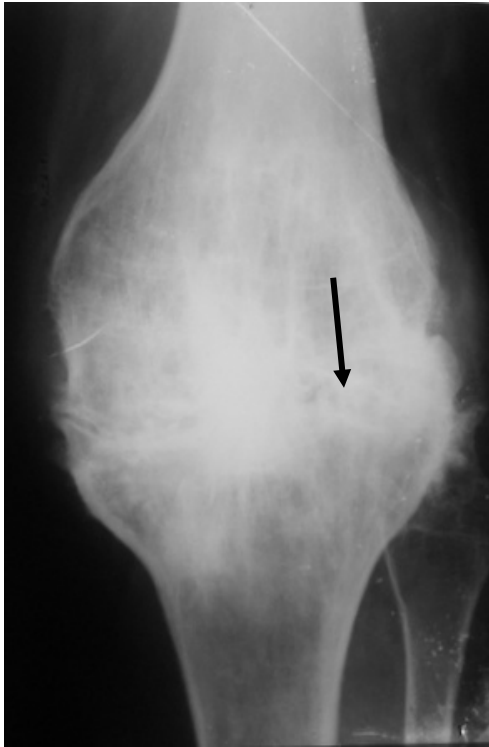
The radiograph of the knee joint in a direct projection. The image of the joint space on the large extent is absent (arrow), subchondral sclerosis, osteophytes is detected. Tubercular ostitis in postarthritic stage. Ankylosis of the knee joint
